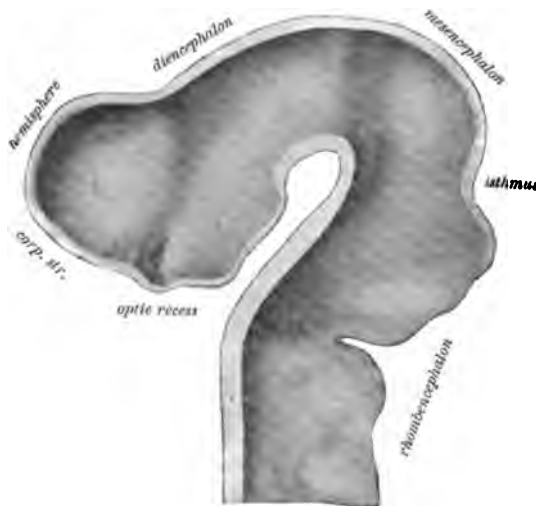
SAME MODEL AS THAT SHOWN IN FIG. 148; MESIAL ASPECT.
